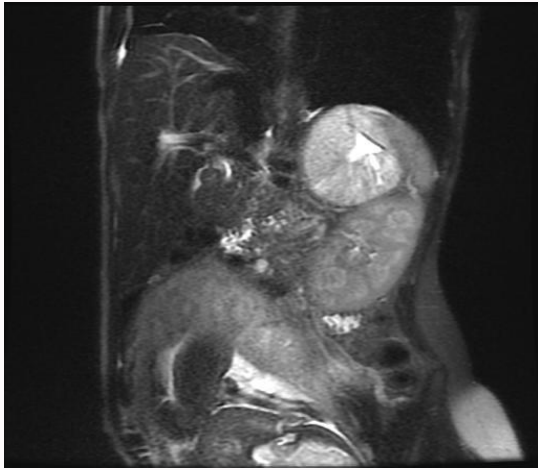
MRI - Coronal T2 single shot shows a 6.7x6.7x6.3 cm T2 hyperintense mass with a central area of increased T2 hyperintensity, in the left adrenal fossa. 135x135 mm (96 x 96 DPI).
